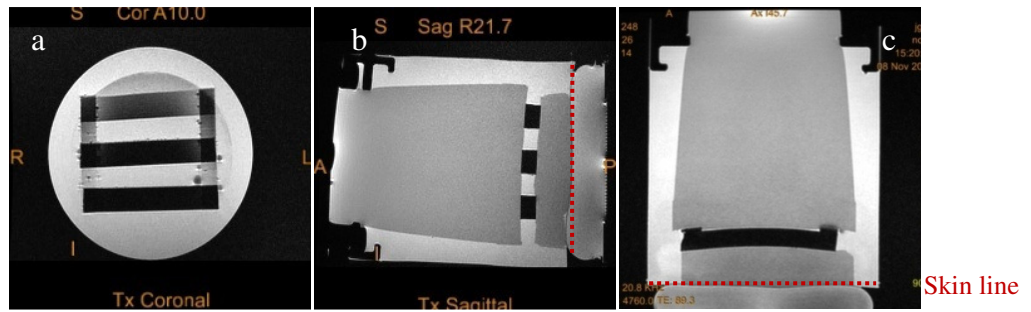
ExAblate 2100 system: MR images showing the experimental setup for the geometric rib sparing study: (a- coronal, b- sagittal and c- axial planes).
